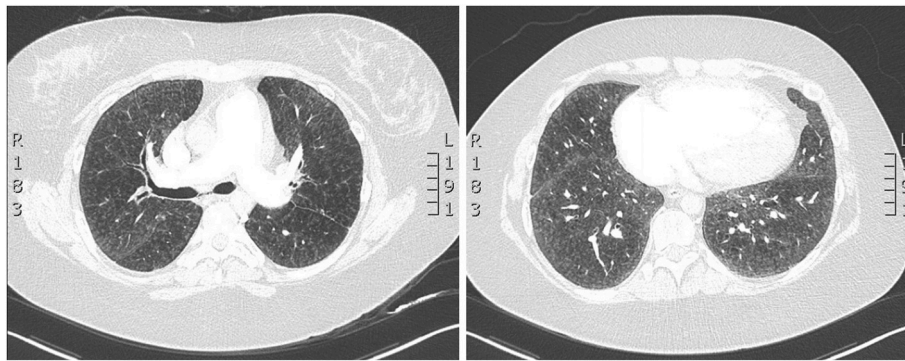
Pre-transplant computed tomography images showing a dilated pulmonary artery suggestive of pulmonary hypertension (left) and extensive, basal-predominant, centrilobular ground glass opacities with smooth septal thickening (right).
